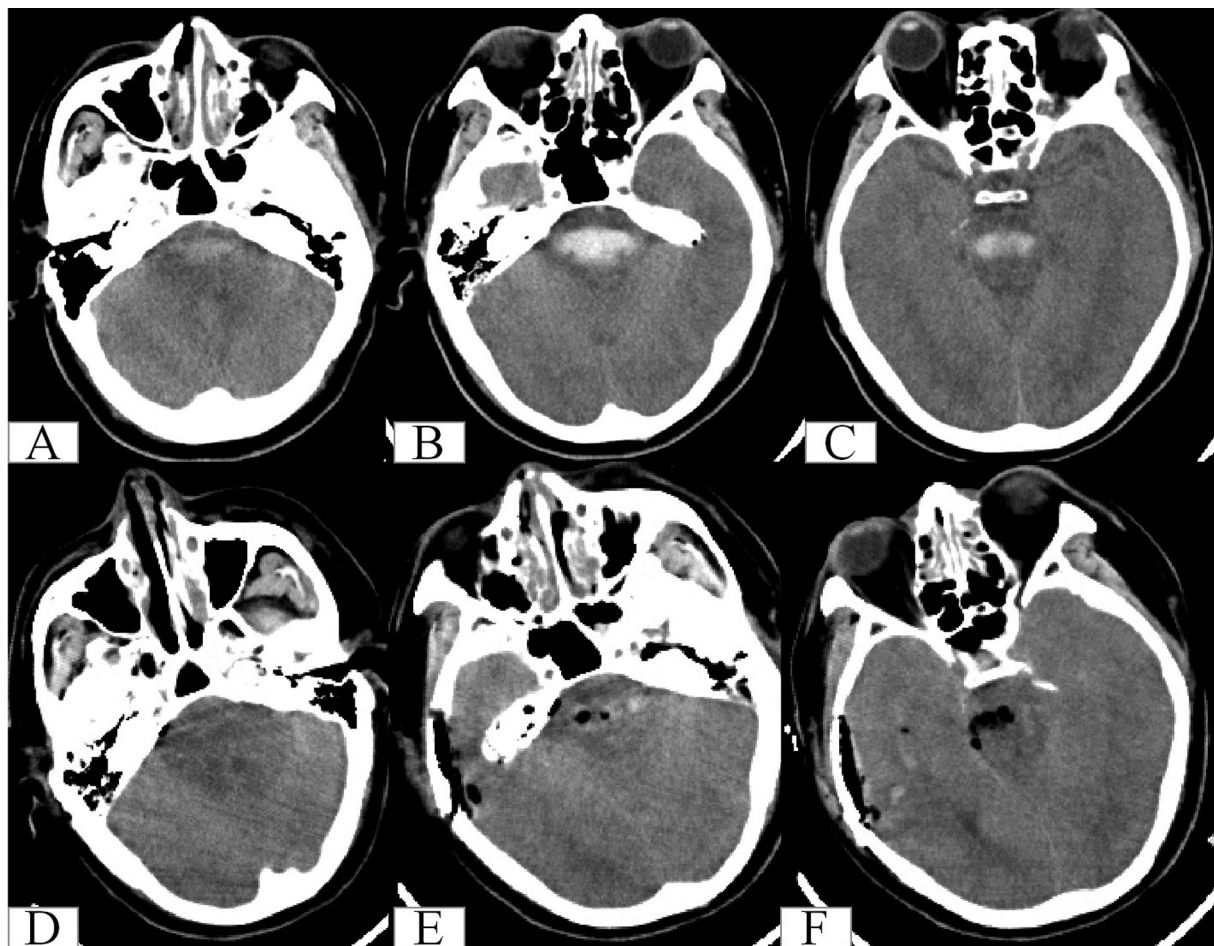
Representative male, 42 years of age with a GCS score of 4 on admission. (A–C) A head CT demonstrated a “basal–tentorial” hemorrhage within the pons. The hematoma volume was ~6.3 mL. Most of the hematoma was evacuated through the right subtemporal tentorial 13 hours after the onset of the first symptom. (D–F) A postoperative CT showed that ~87.3% of the hematoma was removed. The GCS score was improved to 11 one month after surgery and the patient survived showing healthy functioning (GOS score 4). CT, computed tomography; GCS, Glasgow Coma Scale; GOS, Glasgow Outcome Scale.
